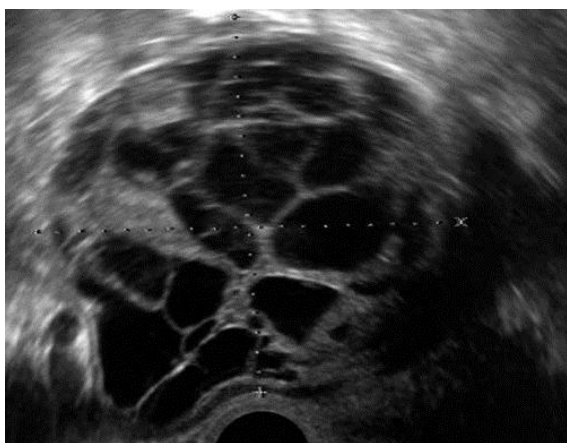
ultrasound image of GCT of ovary showing an multiloculated solid and cystic mass
